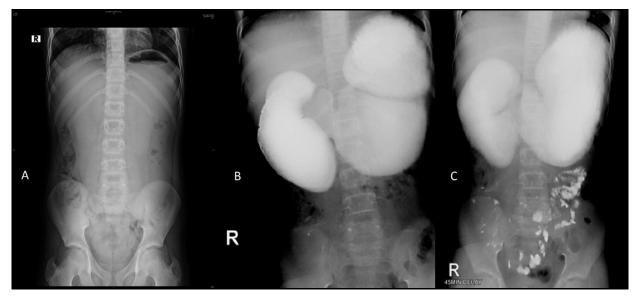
Contrast radiography (A) Erect plain radiograph showing gasless abdomen; (B) Barium meal follow through showing massive dilatation of the stomach and the duodenum with abrupt cutoff at the third part of the duodenum. (C) Delayed picture showing minimal passage of contrast into the distal small bowel.
